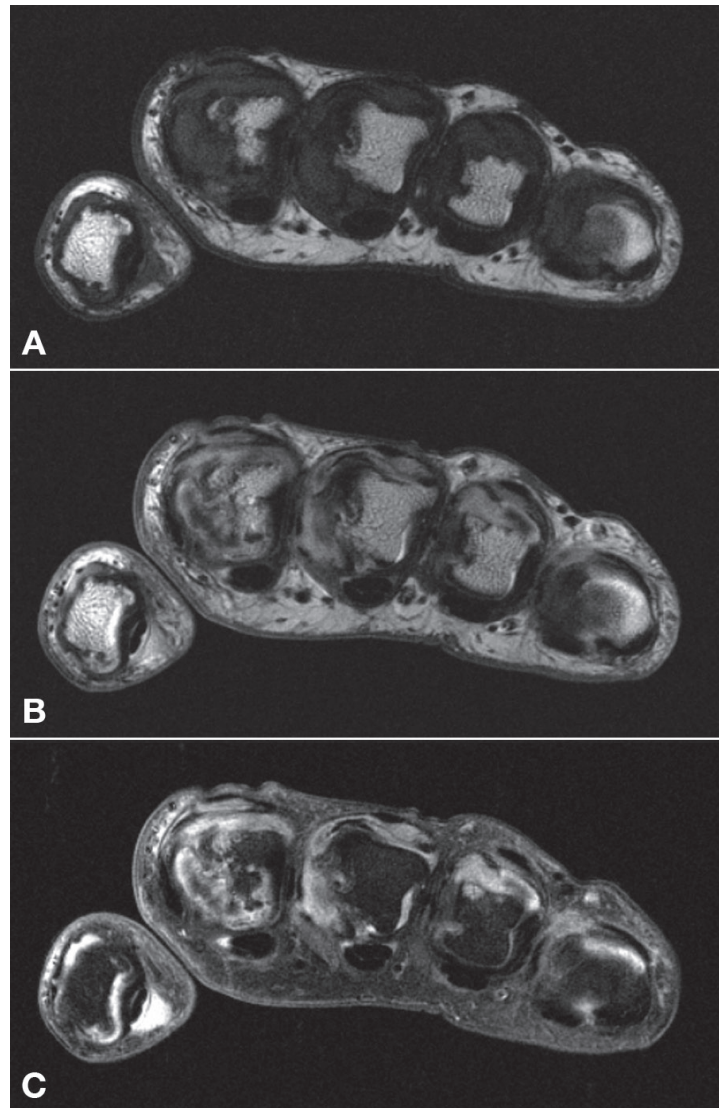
The MCP joints of a patient with rheumatoid arthritis are shown in transverse slice orientation. A. The native T1-weighted sequence shows the thickened synovial membrane as well as erosions of the heads of the metacarpal bones. B. After injection of paramagnetic contrast medium, this synovial membrane appears hyperintense as an expression of active inflammation. C: With the T1-weighted MRI sequence with fat saturation, both erosive destruction and active inflammation can be visualised and differentiated in one image.
